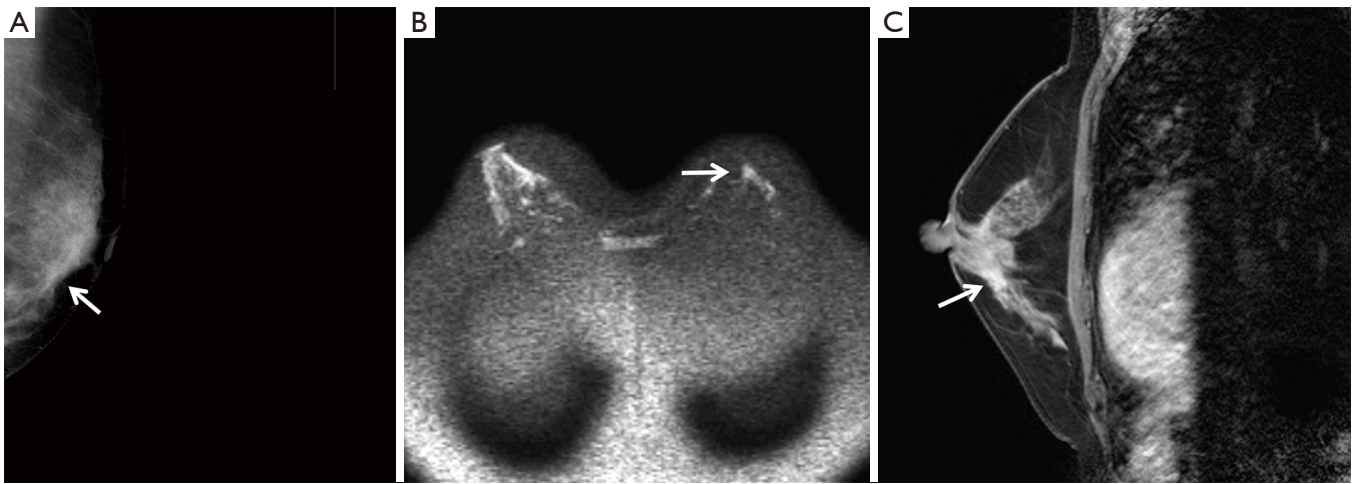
A 46-year-old female patient with left breast adenosis. (A) Craniocaudal view of the FFDM with an architectural distortion in the slightly lower region of the left breast that was in BI-RADS category 3 (arrow); (B) on the MRI diffuse axial view, DWI showed a slightly highly striped signal (arrow); (C) on the MRI enhanced oblique sagittal view, the lesion was enhanced in a patch and belonged to BI-RADS category 3 (arrow). FFDM, full-field digital mammography; BI-RADS, breast imaging reporting and data system.
